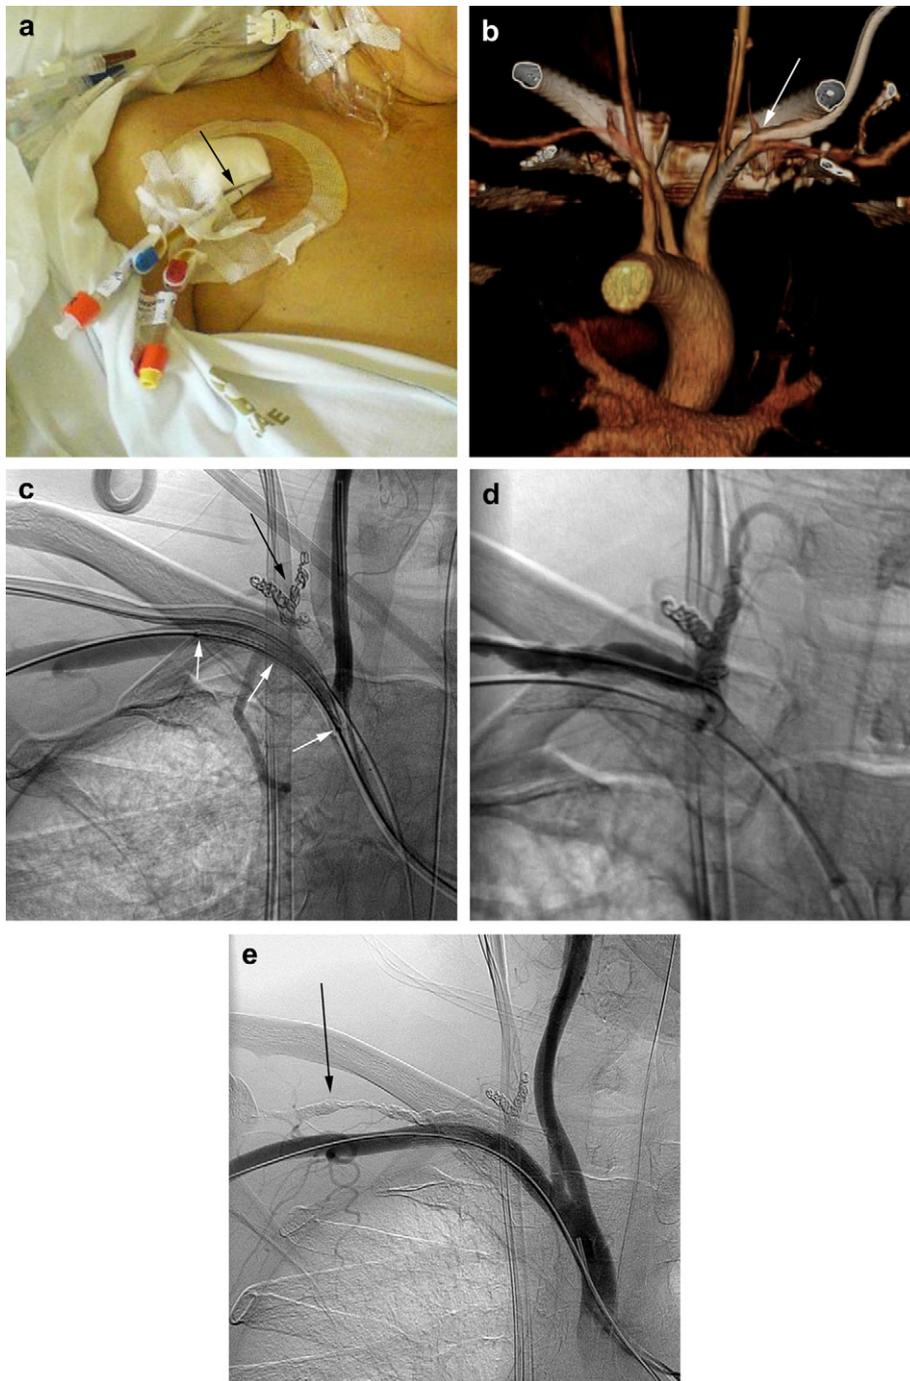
a. In a 61 year old female a 16 Fr double-lumen catheter (arrow) was inadvertently inserted into the subclavian artery, and thereafter another 16 Fr double-lumen catheter was correctly positioned in the internal jugular vein. b. Posterior–anterior three-dimensional reconstruction of computed tomographic angiography showing the 16 Fr double-lumen catheter inadvertently passing caudally to the right clavicle into the right subclavian artery. The arrow indicates the vascular site of catheter entry at the branching of the thyrocervical trunk from the right subclavian artery. c. Angiogram made before withdrawal of the 16 Fr catheter inadvertently placed in the right subclavian artery. An 8 × 50 mm Gore Viabahn® stent graft (white arrows) was placed across the puncture site distally to the right vertebral artery, catheterised separately to secure access in case of overstenting. A 0.018-inch guide-wire passing through the inadvertently placed 16 Fr catheter proved to be most useful after withdrawal of the catheter (d and e). The thyrocervical trunk was embolized with metallic coils (black arrow) to prevent retrograde bleeding. d. Angiogram after withdrawal of a catheter inadvertently placed in the right subclavian artery showing continuous extravasation along the 0.018-inch safety guide partially withdrawn into the subcutaneous channel. e. Completion angiogram showing no further extravasation after embolization with N-butyl cyano-acrylate (Histoacryl; Braun, Melsungen, Germany) mixed with iodised oil (Lipiodol; Laboratoire Guerbet, Roissy, France). The arrow points at the glue in the subcutaneous channel of the inadvertently placed catheter.
